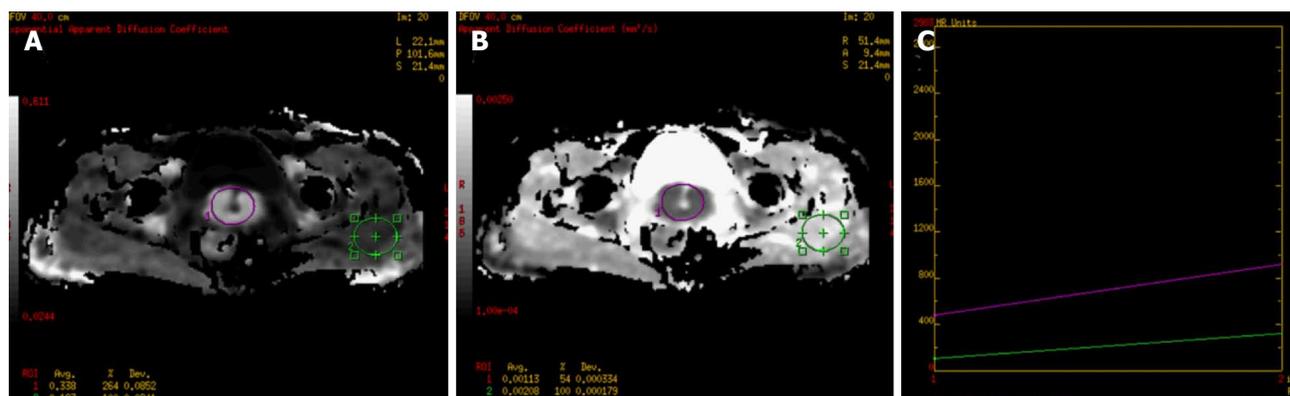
A 59-year-old female presented with post-menopausal bleeding. MRI revealed heterogeneously enhancing mass in the cervix which showed restricted diffusion (A-ROI 1) with low ADC (B-ROI-1) values and higher values on diffusion histogram maps (C) suggestive of malignancy. Biopsy revealed squamous cell carcinoma of the cervix. ADC: Apparent diffusion coefficient; MRI: Magnetic resonance imaging.
